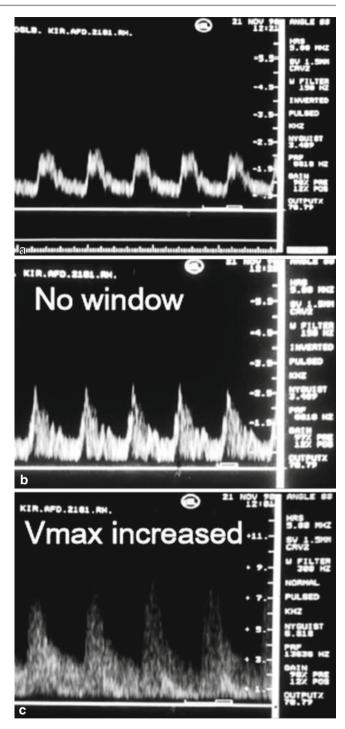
(a) Doppler spectrum from a normal artery, (b) Doppler spectrum from artery <50% stenosis, (c) Doppler spectrum from artery with >50% stenosis
